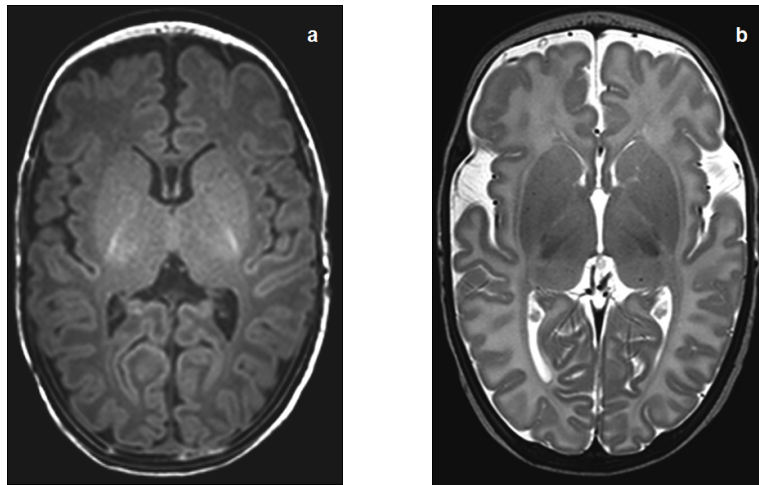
Transverse T_1 - (a) and T_2 -weighted (b) MRI at mid-ventricular level of preterm infant (gestational age 27.9 weeks), scanned after term equivalent age (postmenstrual age 48.7 weeks), showing a single punctate white matter lesion adjacent to the optic radiation (short arrows). Also showing mildly dilated, square-shaped occipital horns of lateral ventricles (long arrows) (MRI white matter score: normal/mildly abnormal).
